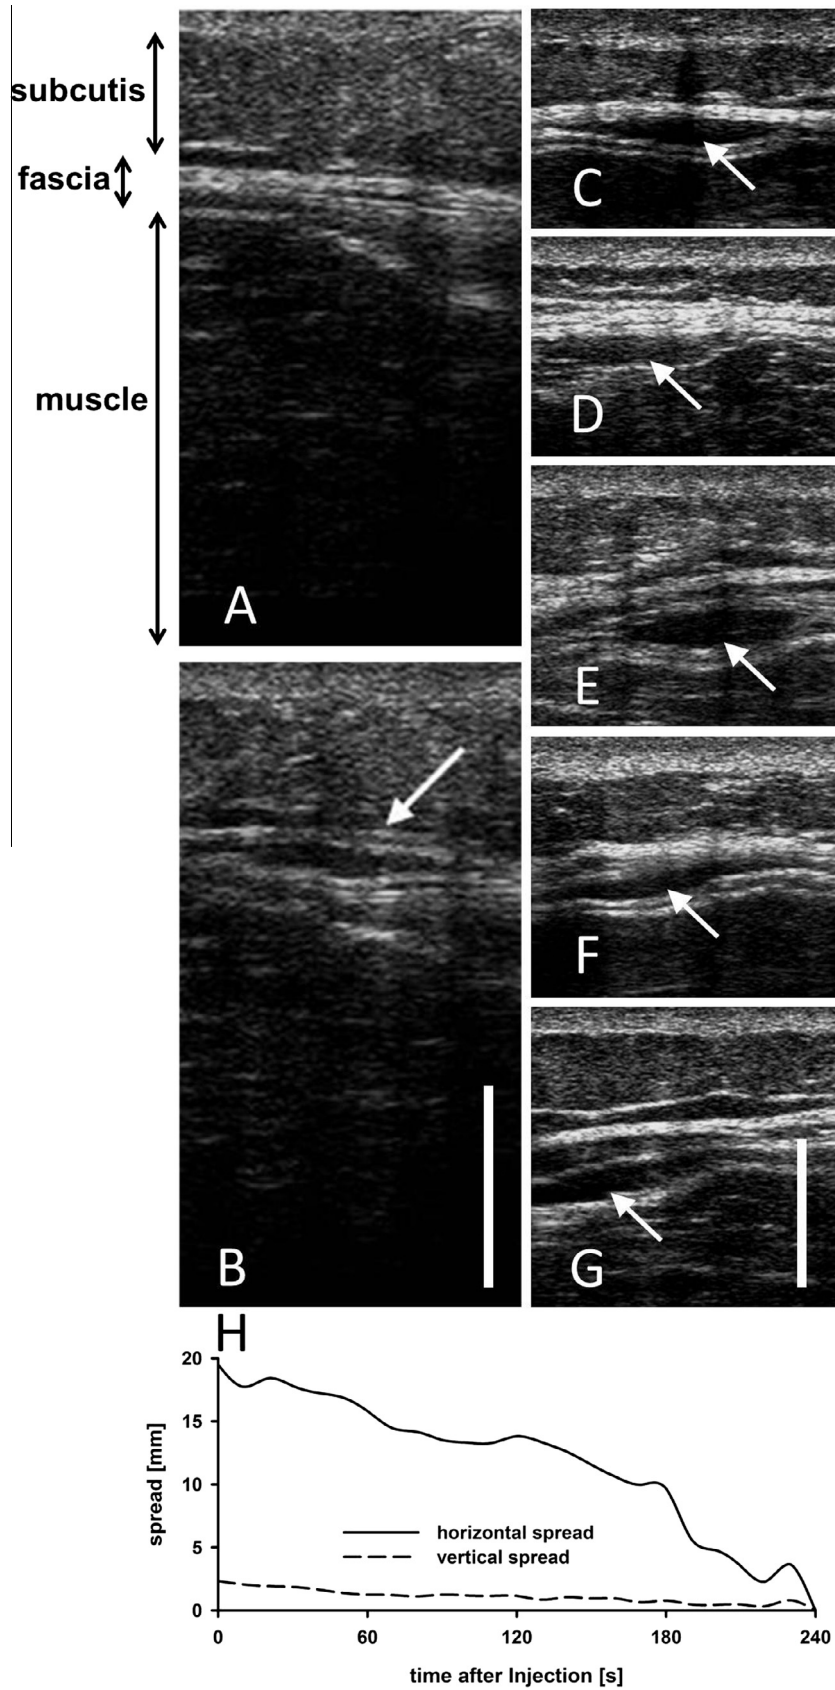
Ultrasound images of the subcutis, the thoracolumbar fascia, and the erector spinae muscle before (A) and approximately 3 seconds after (B) the injection of hypertonic saline into the fascia (white arrows; scale bar: 1 cm). (C–G) Examples of ultrasound images of fascia injections in 5 additional subjects. (H) Average time course of volume spread in 3 subjects after fascia injection of hypertonic saline measured as horizontal (solid line) and vertical spread (dashed line).
